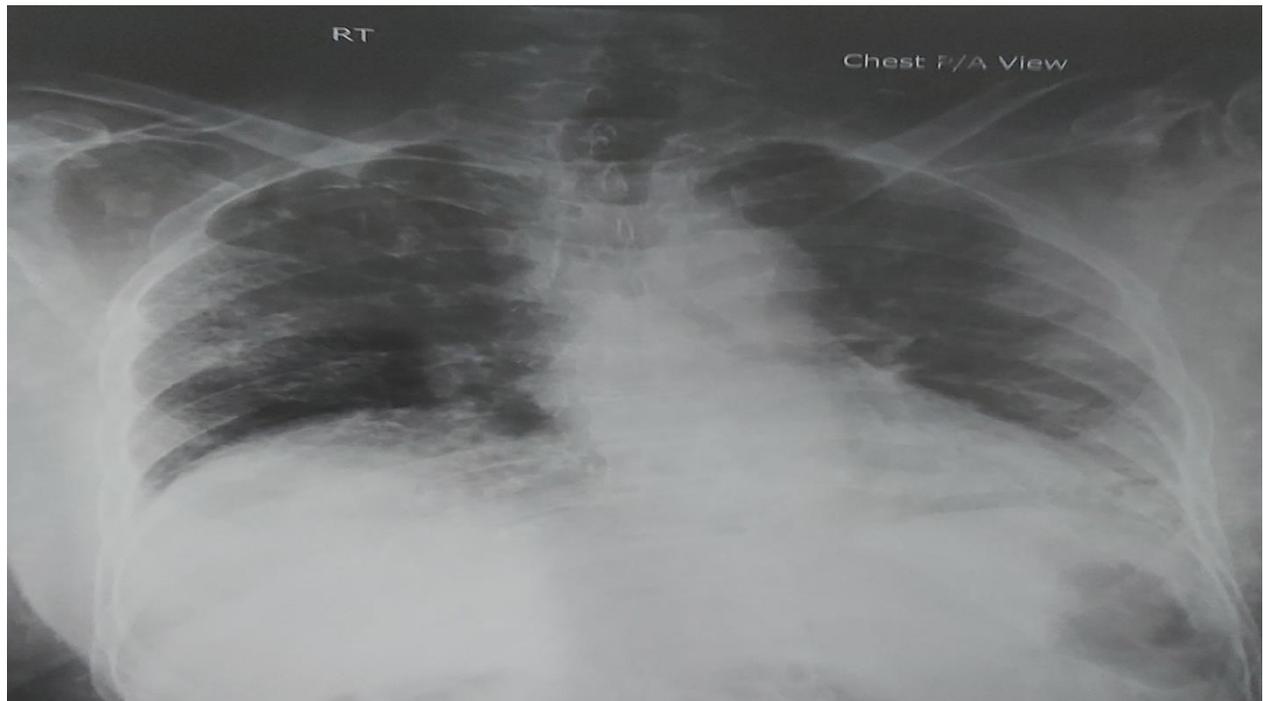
Follow Up X-ray chest showing patchy opacities are noted in both hemi thorax. (Radiological improvement lagged behind the clinical improvement).
